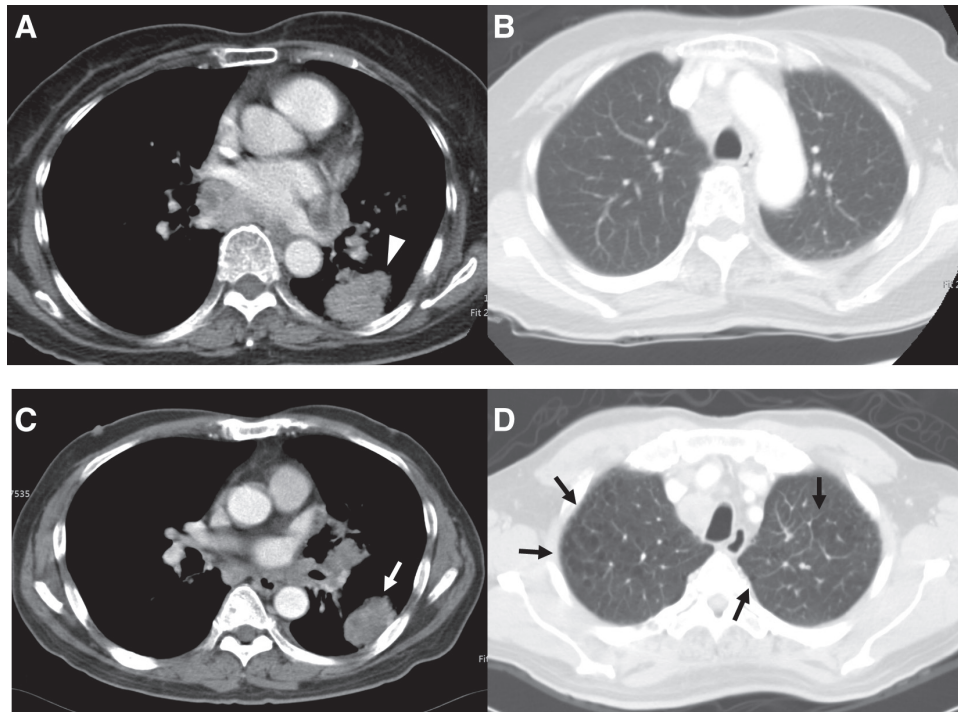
(A–D) A 64-year-old woman with stage 4 LELC. A CT scan with mediastinal window (A) and lung window of upper lung field (B) demonstrates a tumor situated in the LLL. A 69-year-old man with stage 4 SCLC. A CT scan with mediastinal window (C) and lung window (D) demonstrates a tumor situated in the LLL. Both tumors are located peripherally with a lobulated border. However, LELC (white arrowhead) shows more prominent (81 HU and 42% higher than right erector spinae muscles) and homogeneous enhancement compared to SCLC (white arrows) with less prominent (60 HU and 2% higher than right erector spinae muscles) and heterogeneous enhancement. Emphysematous change of the upper lung fields is conspicuous in the SCLC (black arrows). CT = computed tomography; LELC = lymphoepithelioma-like carcinoma; LLL = left lower lobe; SCLC = small-cell lung cancer.
